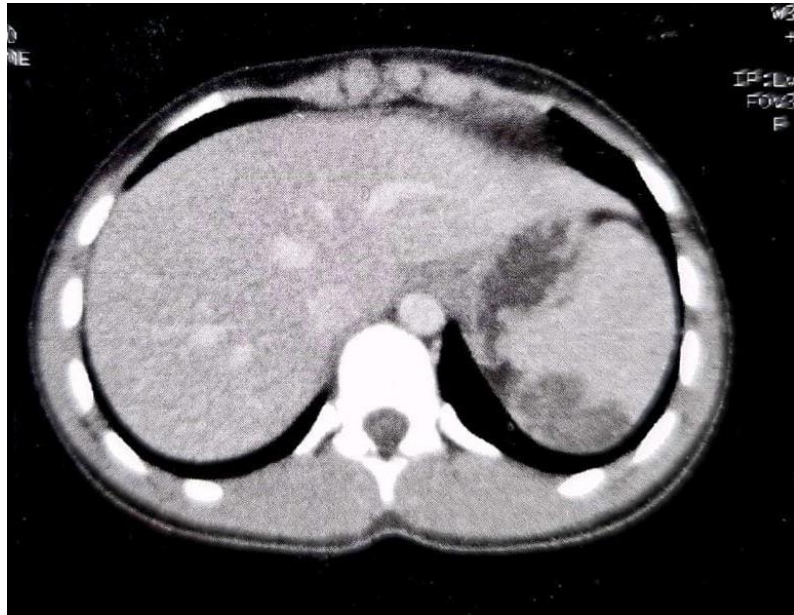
Abdominal CT scan showing a posterior mid-splenic cystic lesion
